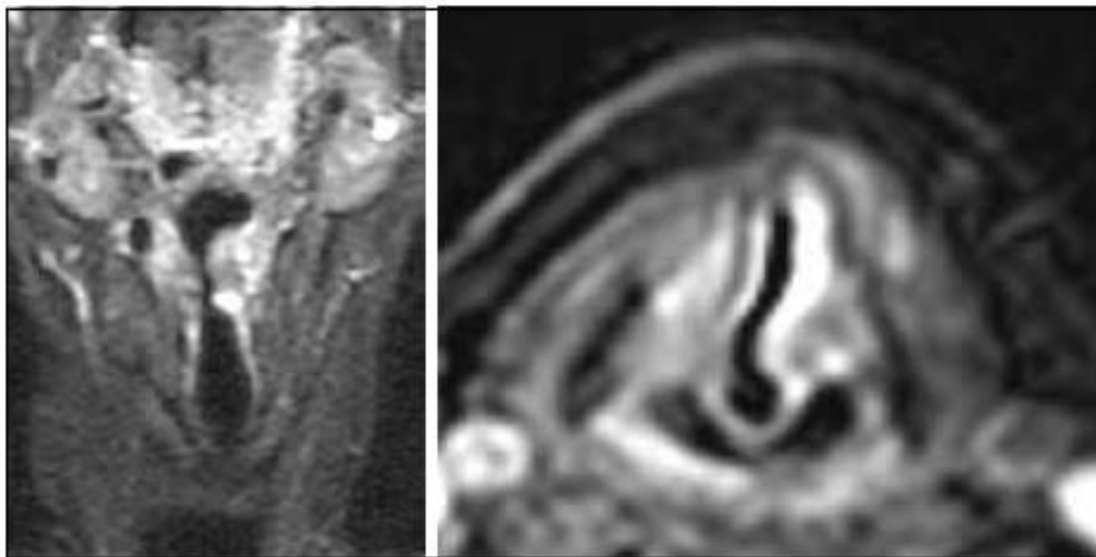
a-b) MRI in coronal and axial view of recurrent papillary thyroid carcinoma with thyroid cartilage involvement and intralaryngeal spread.
